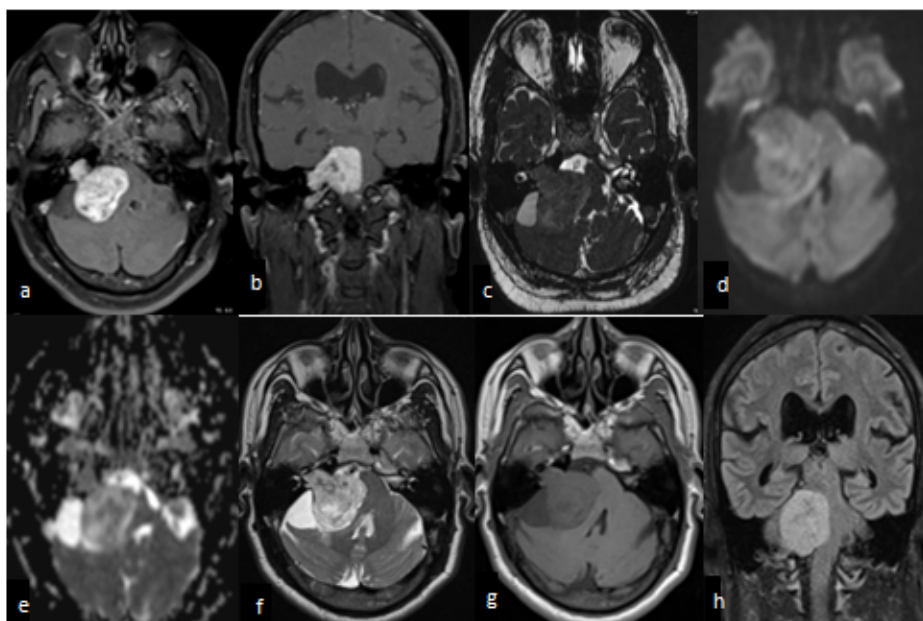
Large vestibular schwannoma in patient presenting with dizziness, right deafness and chronic headache (a,b) Contrast enhanced axial and coronal T1-weighted image and (c) Constructive interference in steady state axial image and shows typical “ice cream on-cone” CPA mass lesion that heterogeneously enhances. The component enlarging the porus of the internal auditory canal is very suggestive of the diagnosis. (d,e) The lesion show heterogeneous diffusion restriction. (f) T2-weighted imaging showing right sided cerebellopontine angle intracanalicular tumor compressing the pons, 4th ventricle and adjacent cerebellar hemisphere. (g) It is hypointense on T1-weighted imaging and (h) hyperintense on FLAIR
